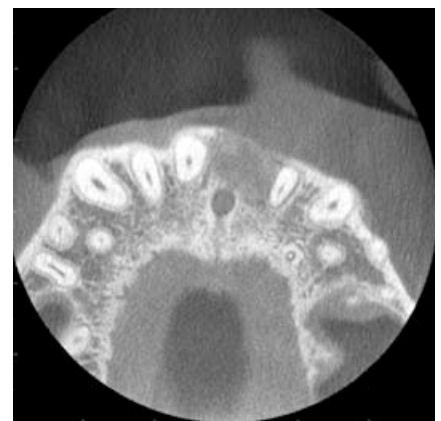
Axial CBCT image
